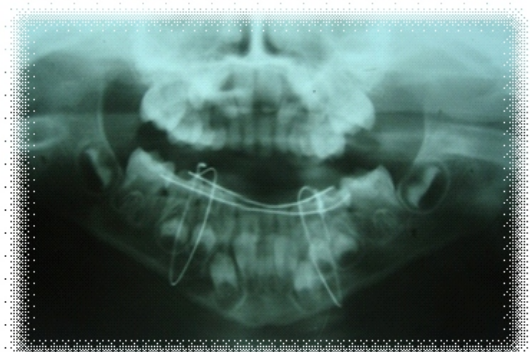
(a): CASE-1 post operative radiographic with cap splint
